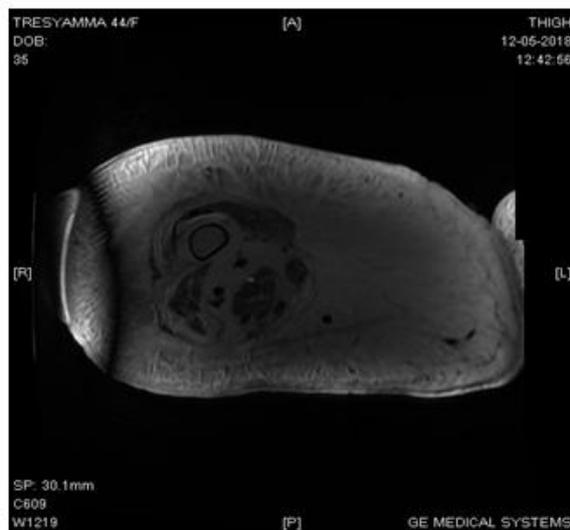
MRI showing cut section of (R) thigh. Figure 2: Pre-excision and Post-excision limb.
